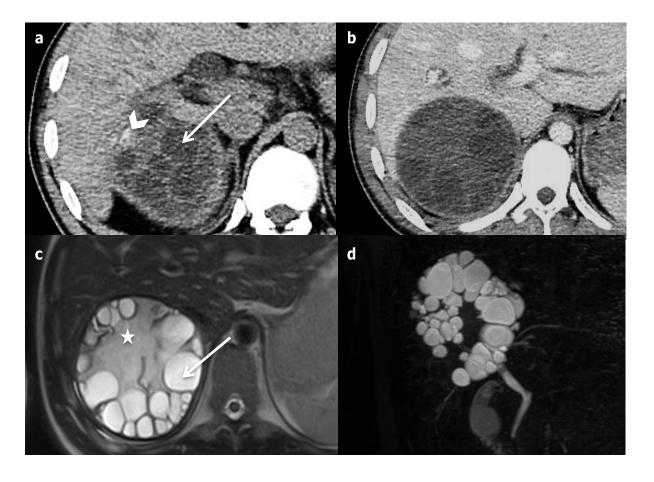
Cyst echinococcosis 2 in a 50-year-old male patient. (a) Axial non-enhanced computed tomography shows heterogeneous mass with cystic part (arrow) and calcification of the wall (arrowhead). (b) At axial portal-venous phase computed tomography there is no enhancement of the cystic component. (c) The cystic part and the differentiation between the daughter (arrow) and the mother (star) cysts are better evaluable at axial T2-weighted magnetic resonance imaging. (d) Coronal 3D magnetic resonance cholangiopancreatography eliminates biliary fistula.
